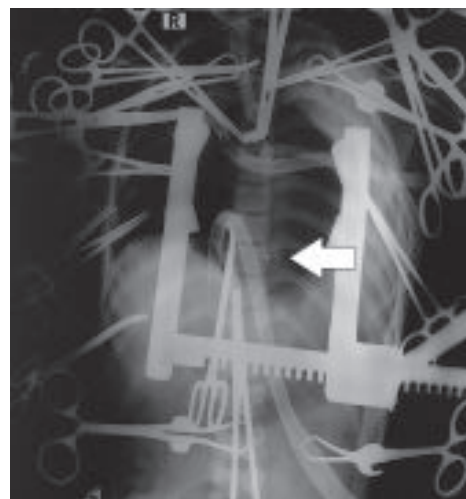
On-table portable X-ray shows embolized ASO device in the descending thoracic aorta (arrow)
